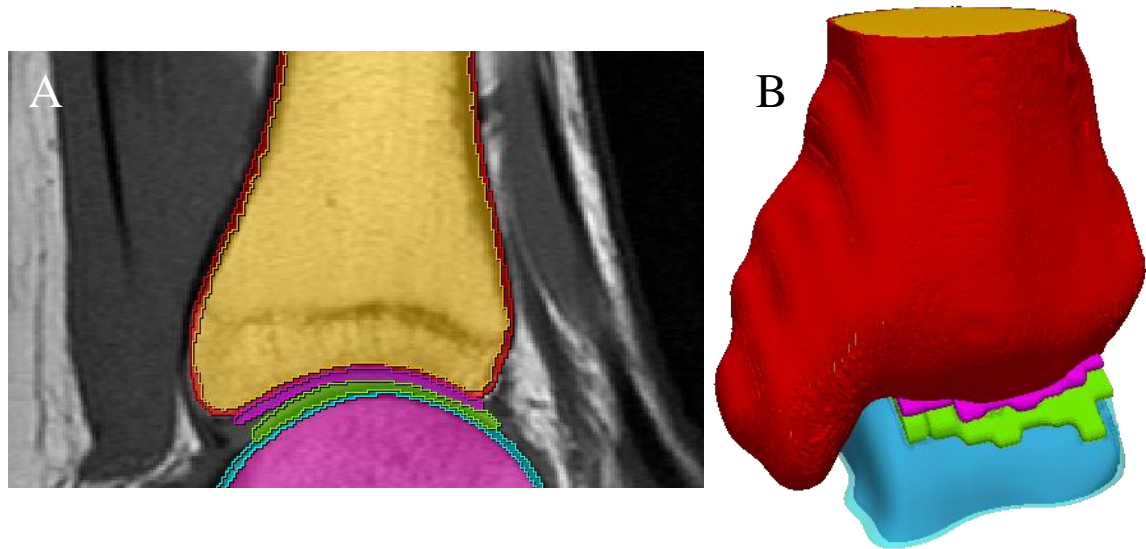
Split layered bone model, A) with translucent uniform thickness overlaying MRI image, and B) reconstructed model with 50% translucency applied to cortical talar layer
